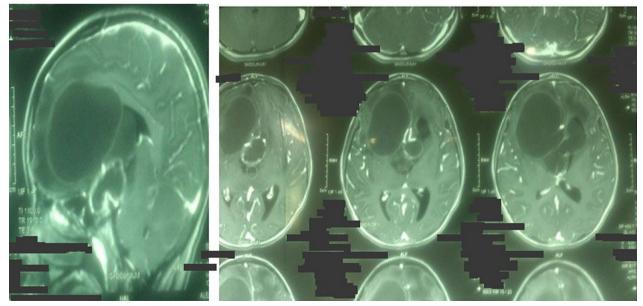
Preoperative MRI of patient 1
